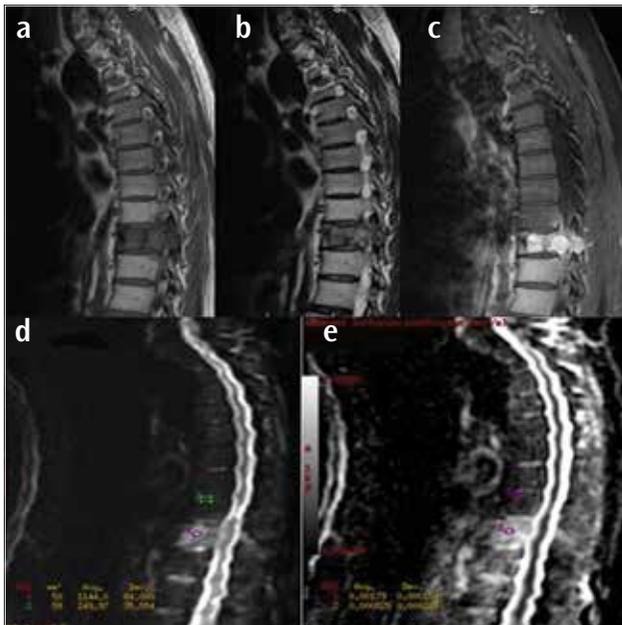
a-e. A 61 year-old renal RCC patient presenting with T10 vertebra metastatic fracture, sagittal T1-weighted image shows hypointense, sagittal T2-weighted image (a) shows hyperintense signals of fractured vertebrae. Sagittal fat-saturated contrast-enhanced T1-weighted image (b) shows marked contrast enhancement of vertebra. Sagittal DWI (c) and sagittal ADC images shows hyperintense signals of fractured vertebrae (d) ROI measurements were also performed from normal (T9) and fractured vertebrae. DWI values of T9 and T10 vertebrae were 2 and 1144, respectively. ADC values of T9 and T10 vertebrae were 0.52×10^{-3} mm²/s and 1.79×10^{-3} mm²/s, respectively (e)
